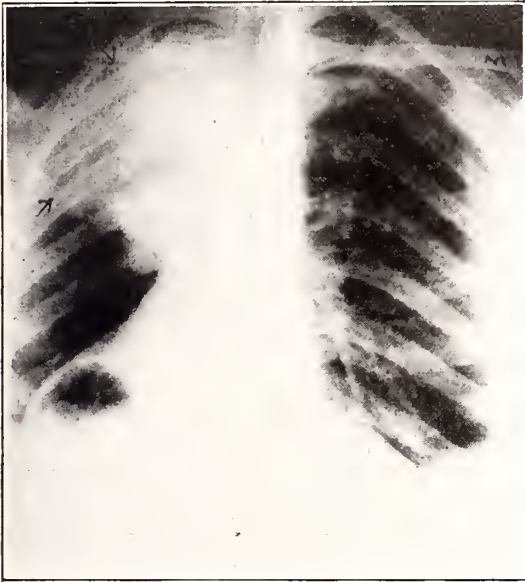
Same case showing radiograph 5 months after onset of symptoms of carcinoma of the lungs.
